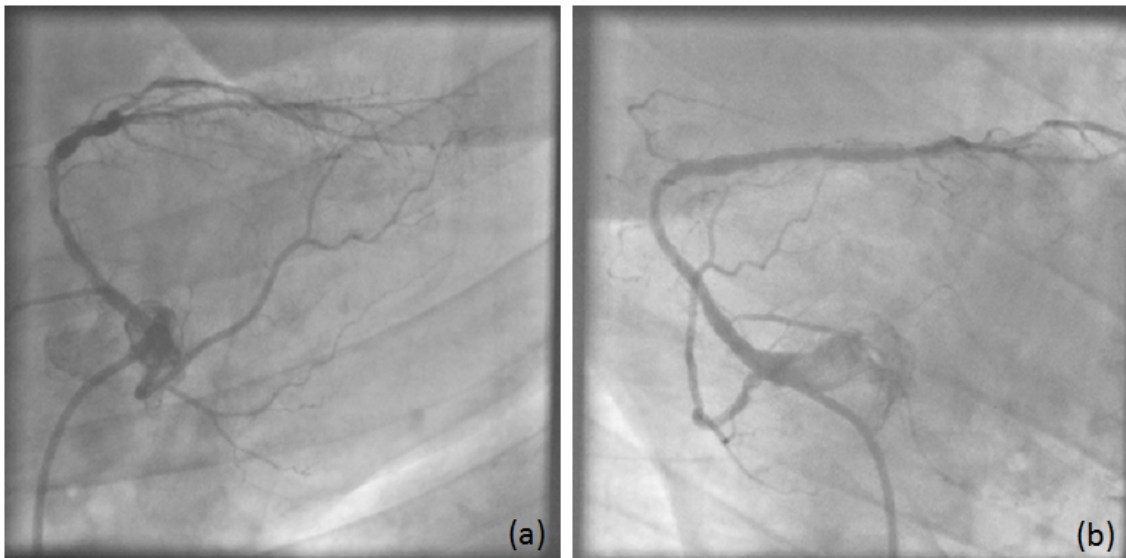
Biplane X-ray angiograms of coronaries: (a) view 1 of angle 40 and (b) view 2 of angle 45.
